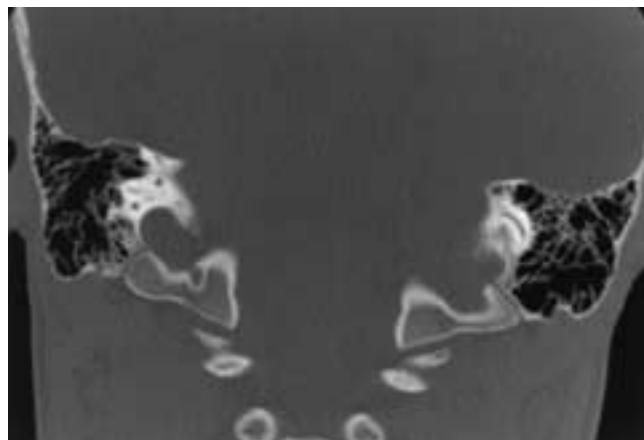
Pseudo-fracture, occipitomastoid sutures. This magnified coronal CT image of the left ear demonstrates normal occipitomastoid sutures (*arrows*). They are symmetric and smoothly corticated in this example, but may be irregular and asymmetric and still be within the range of normal.
